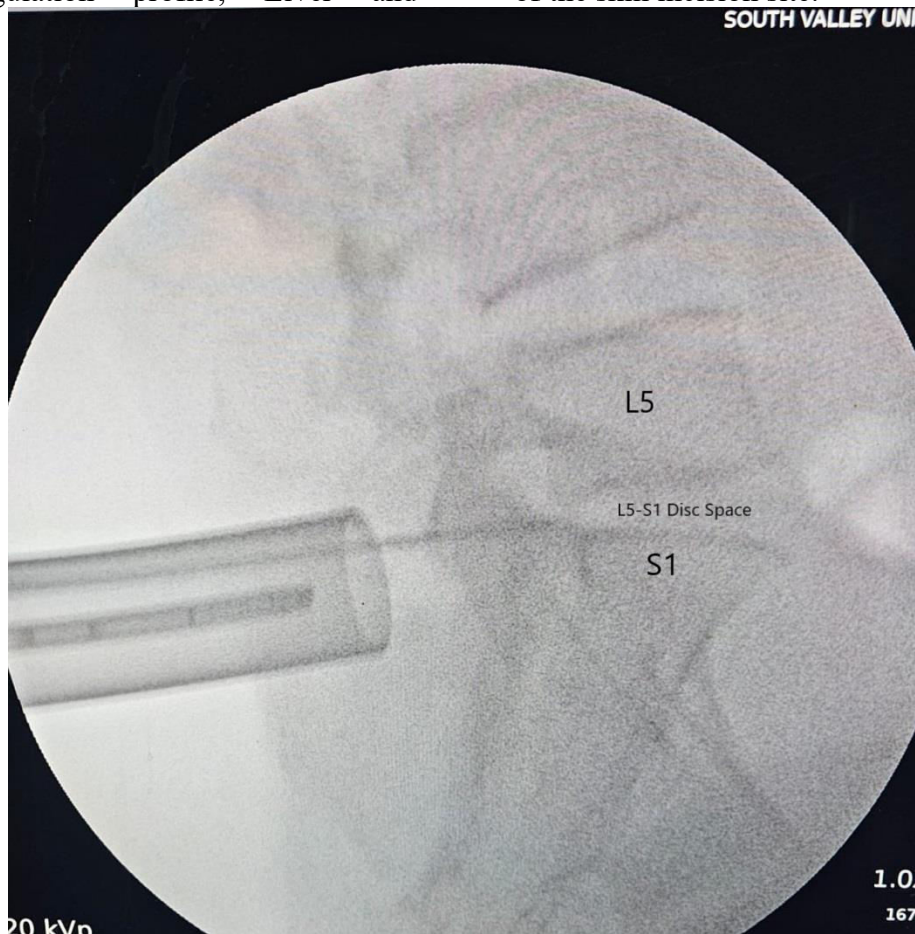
Intra-operative x-ray "lateral view" showing the site of PEILD at L5-S1.
